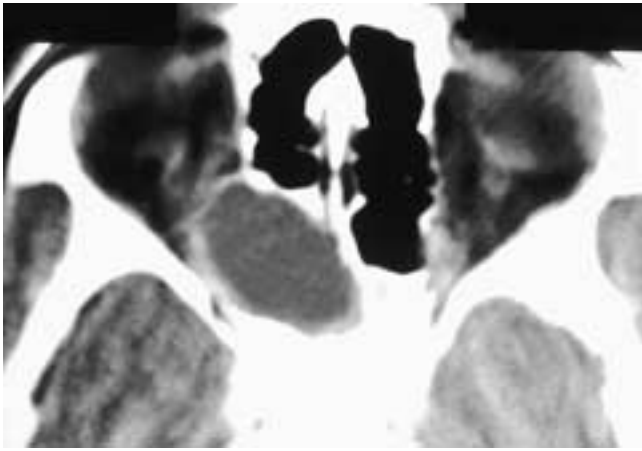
Axial CT scan shows a water attenuation, expansile mass in the right posterior ethmoid/sphenoid sinus area. The mass displaces the optic nerve and medial rectus muscle downward and laterally. This patient had a sphenothmoidal mucocoele. In these cases, the radiologist must carefully note the position of the optic nerve in relationship to the mass in order to help guide the surgeon away from intraoperative complications.
